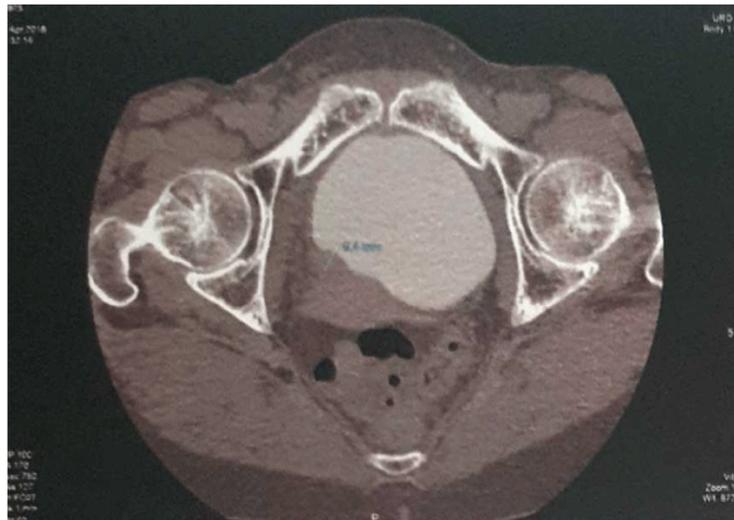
CT urographyrevealed a tissue process of the right vesicalwall
